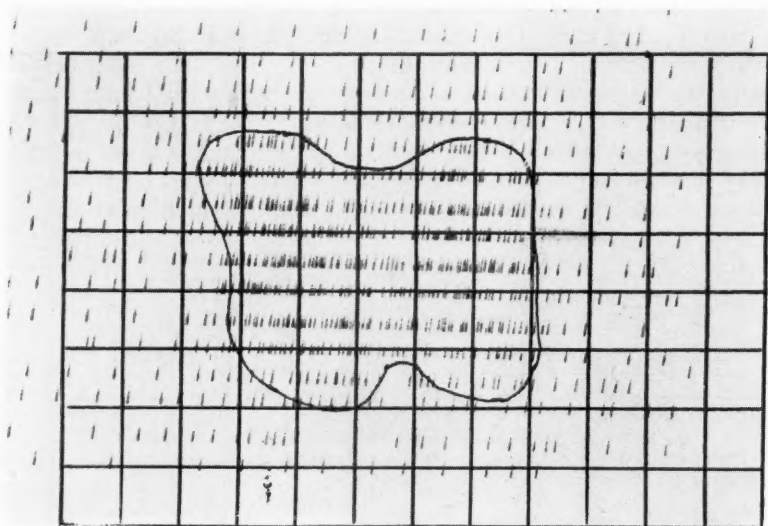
A thyroid scintigram. The determination of thyroid weight by the formula $W = A \times H \times .32$. In this case the height of the lateral lobes is 4 cm. and the frontal area is 20 cm.² By substitution in the formula we find the gland weighs 24 gm.
